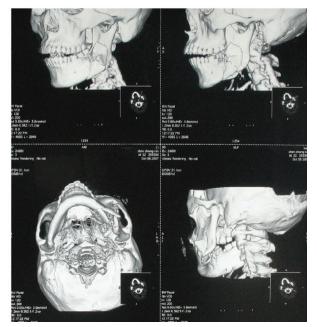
Computed tomography (CT) scanning images (3D reconstruction): comminuted fracture of the left mandible.
